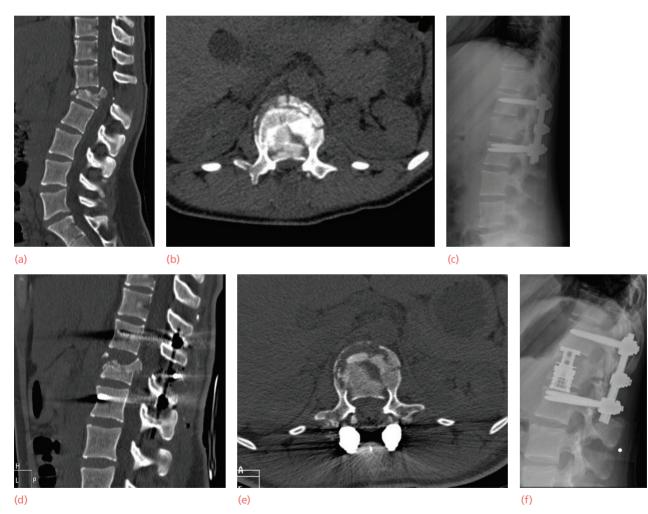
Burst fracture – treatment (a,b) L1 burst fracture in an 18-year-old female; CT demonstrates a large interspinous gap (PLC disruption) and fragments retropulsed into the canal. (c) Simple posterior fixation with Shantz screws allows kyphosis correction and distraction with indirect canal decompression and anterior column restoration. (d,e) Persistent neurological symptoms prompted repeat CT showing remaining significant fragment in the canal. (f) Anterior decompression and reconstruction with an expandable cage resolved the neurological deficit.
